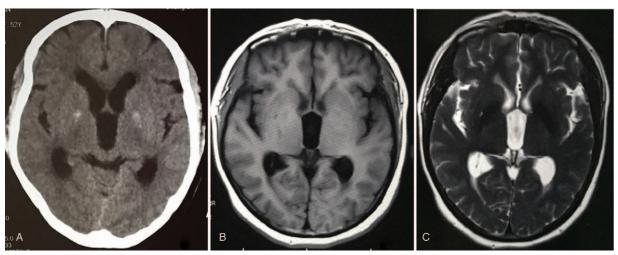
Head computed tomography (A) and magnetic resonance imaging (B and C) images show enlarged ventricles.
